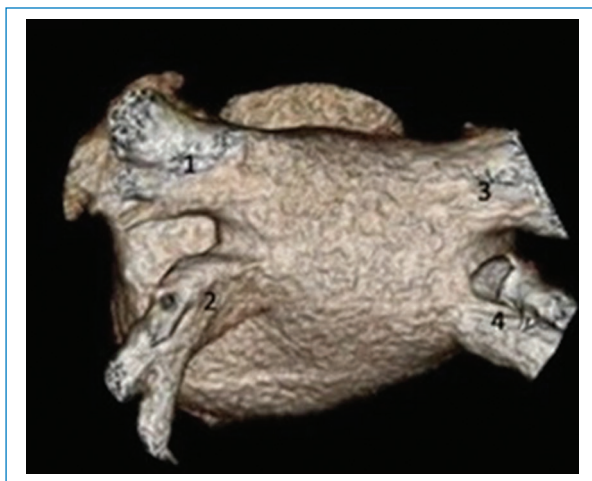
Three-dimensional reconstruction of a CT angiogram depicting the normal anatomy of the pulmonary veins (adapted from Lyen et al.⁷). 1: left superior pulmonary vein. 2: left inferior pulmonary vein. 3: right superior pulmonary vein. 4: right inferior pulmonary vein.
